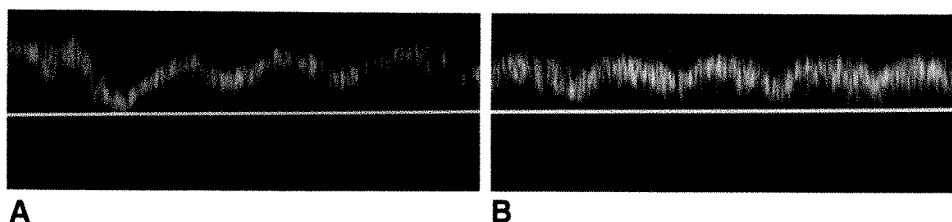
A, and B, Doppler tracing shows pulsatile venous signal in a patent paraumbilical vein (A). Pulsatility is not of arterial type and is similar to that seen in left portal vein (B) in same patient.
